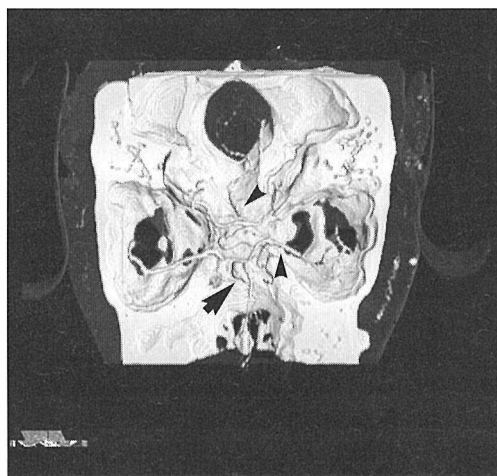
CT angiogram, volume rendering technique, superior view, shows vasospasm of intracranial arteries (arrowheads) after subarachnoid haemorrhage and an anterior communicating aneurysm (arrow).
